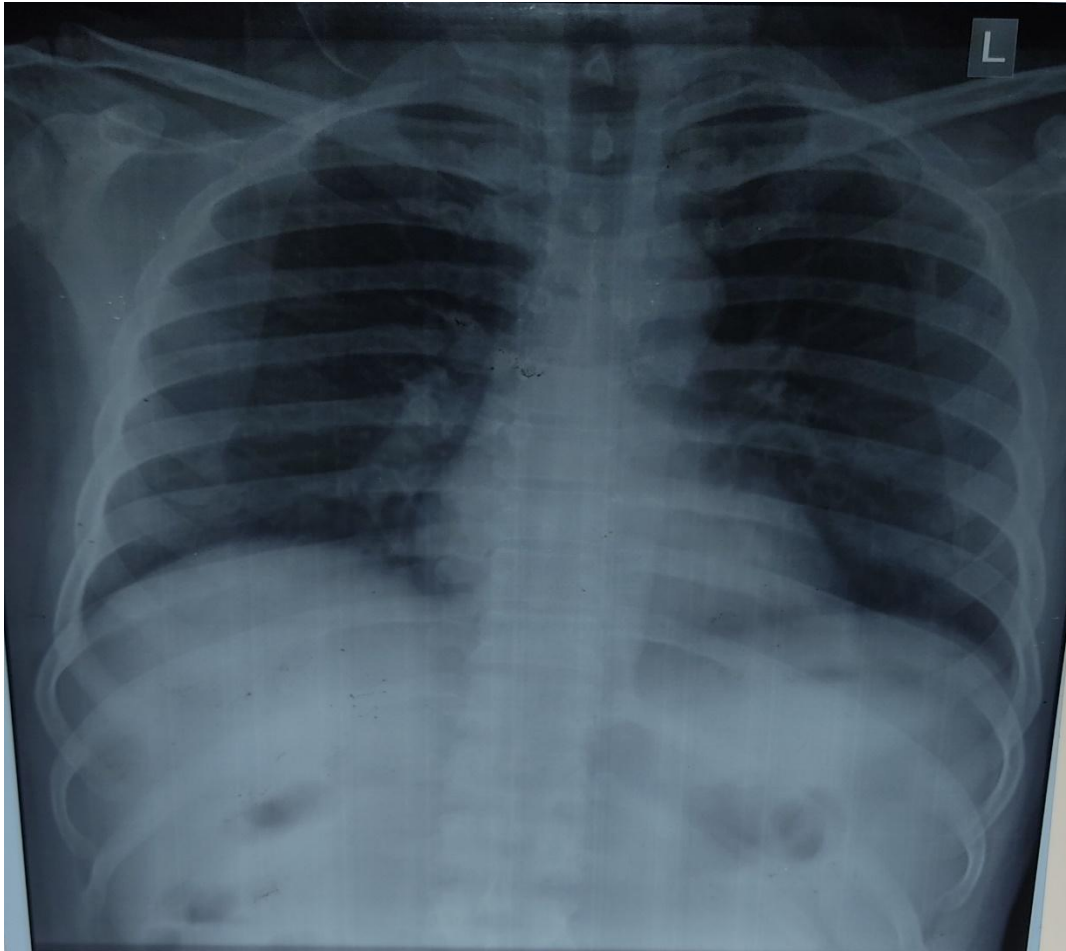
chest radiograph showing no abnormality on discharge.
